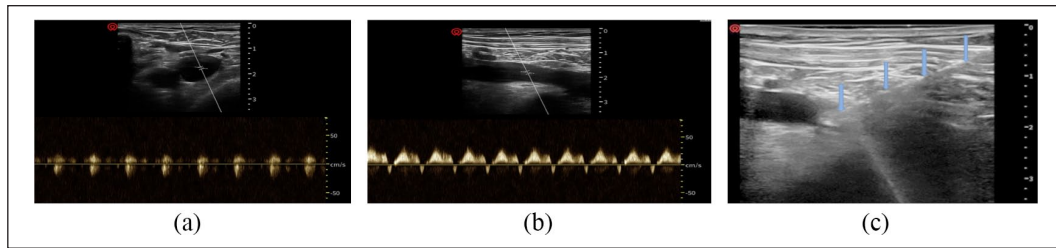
Short-axis/transverse image (a), longitudinal or in-plane view (b) of the right axillary vein, and ultrasound-guided puncture of the right axillary vein under the in-plane technique (c). The needle is seen as a hyperechoic linear structure (blue arrows).
